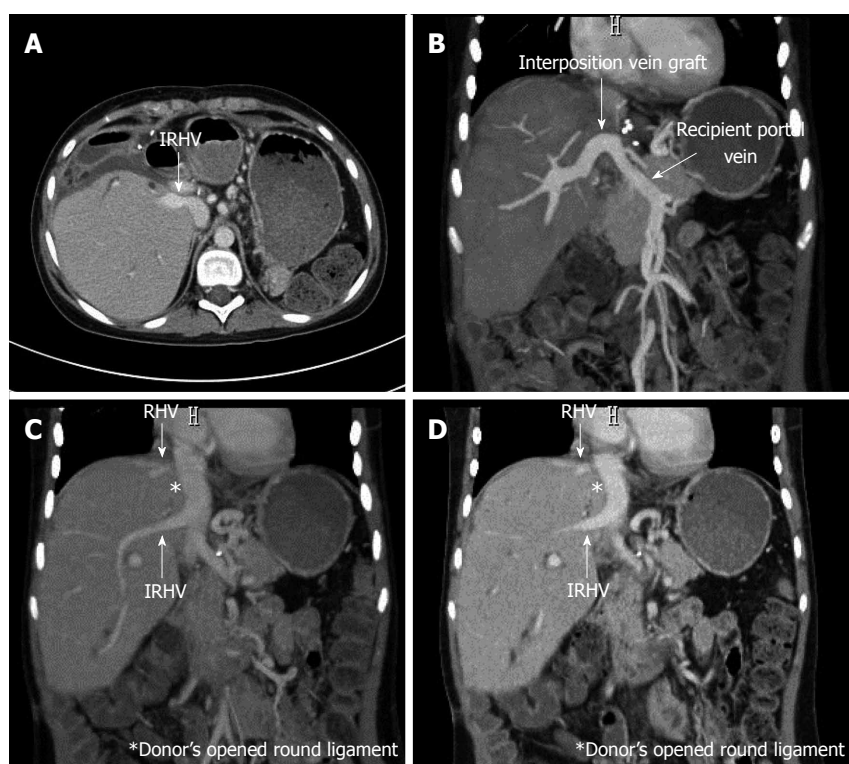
Abdominal enhanced computed tomography on post-operative day 82. The radiological patency of the donor's opened round ligament and the hepatic vein was confirmed (A, B, C, D). RHV: Right hepatic vein; IRHV: Inferior right hepatic vein.
